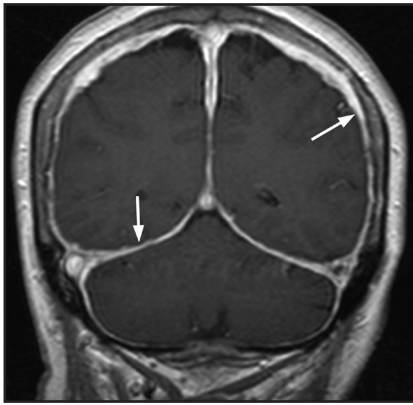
Coronal T1-weighted MRI with contrast demonstrating typical smooth, diffuse, pachymeningeal enhancement (arrows).
